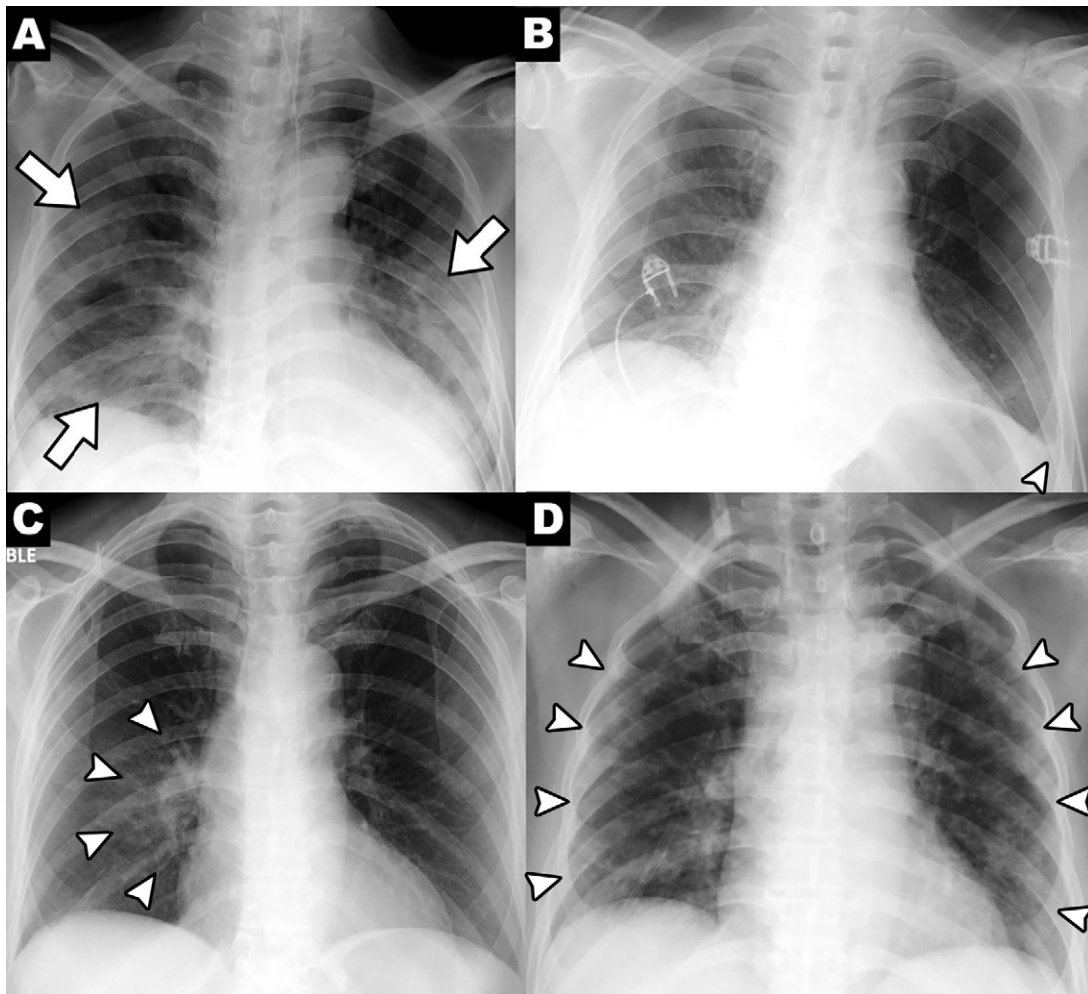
Findings on chest radiographs in patients with coronavirus disease 2019. A, Patchy consolidations (arrows) in a 69-year-old male patient, B, pleural effusion (arrowhead) in an 80-year-old male patient, C, perihilar distribution (arrowheads) in a 59-year-old female patient, and, D, peripheral distribution (arrowheads) in a 57-year-old female patient are shown.
